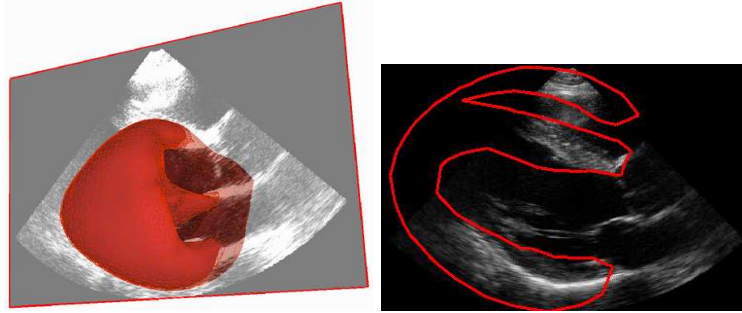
Left: the 3D model in a slice of the 3D ultrasound image. Right: intersection of the model and the image.
